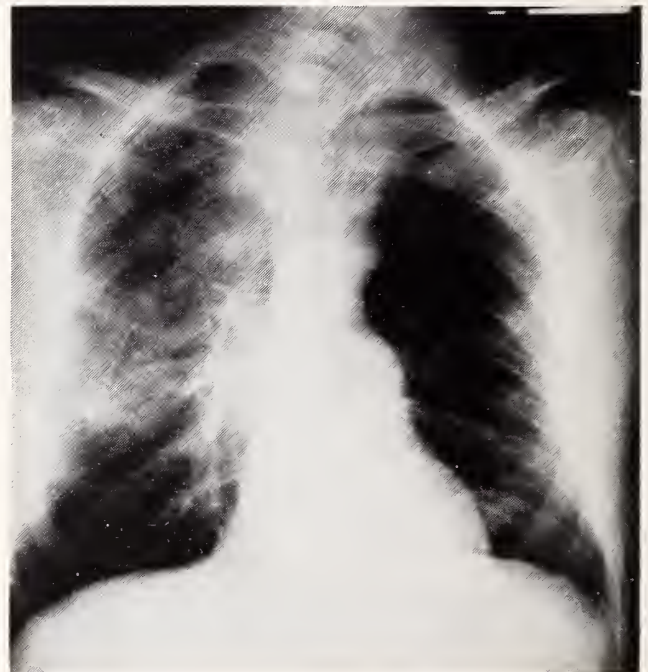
Chest x-ray prior to discharge. Further resolution of the right lung infiltrate has occurred. Again, note the extensive rib deformity on the right side.
